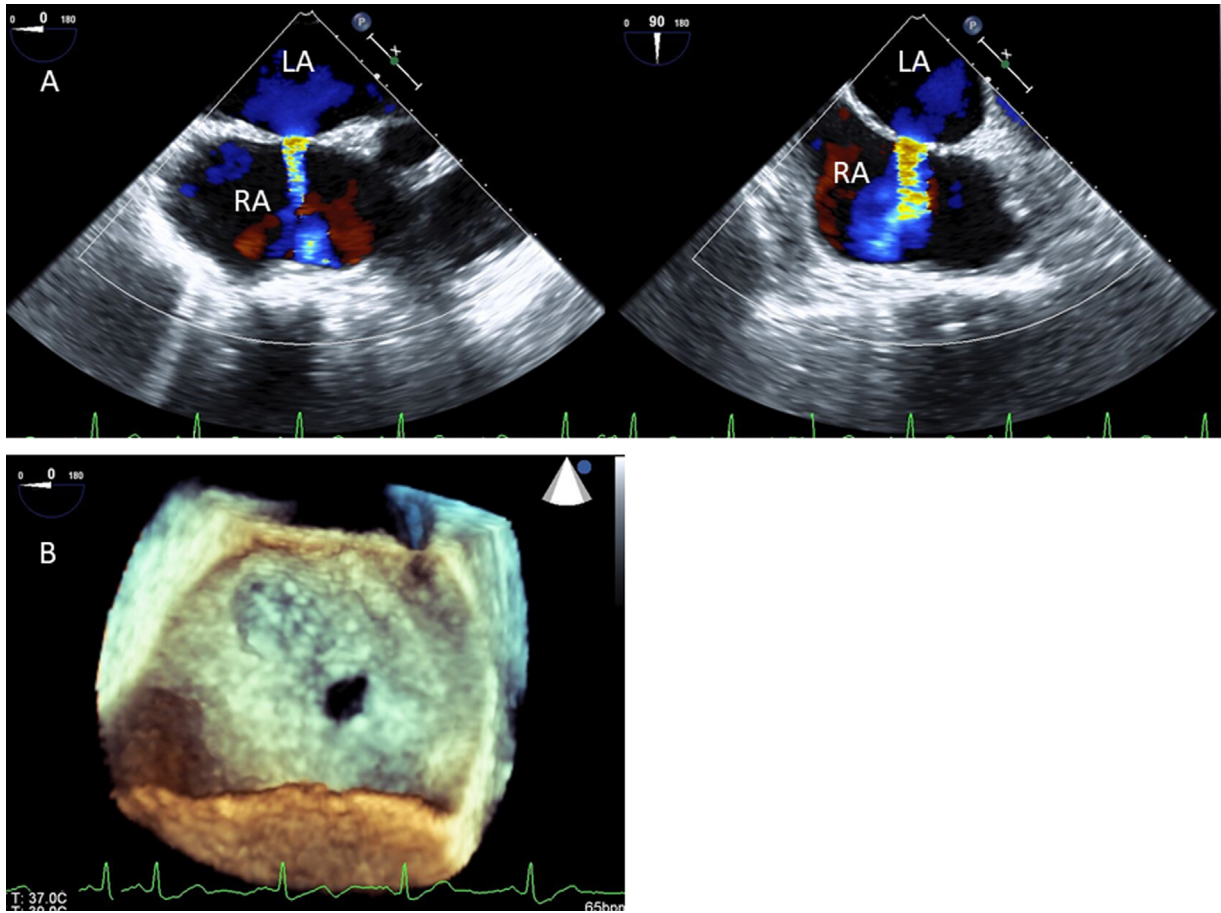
Two-dimensional transesophageal echocardiography (TEE) showed a single atrial septal defect with a single shunt flow (A) (left: 0°, right: 90°). Real-time 3D-TEE showed one central hole in the interatrial septum (B). LA, left atrium; RA, right atrium.
